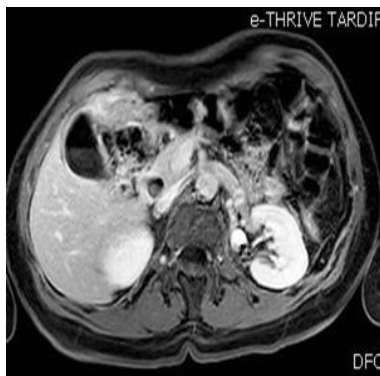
Biliary MRI with dilation of the overlying bile duct
